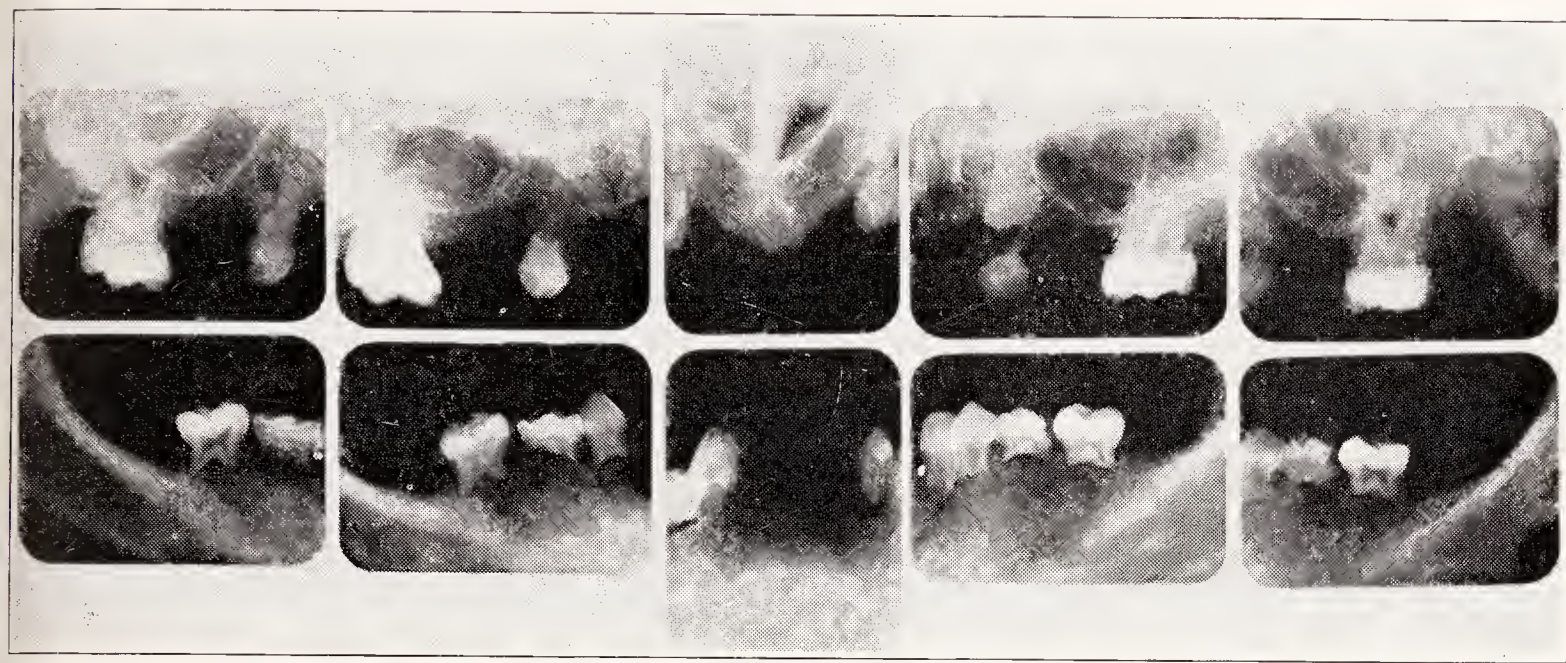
Radiographs of a girl, aged thirteen years, with almost complete anodontia. The only teeth present are several deciduous teeth and three upper permanent molars. Note the extensive resorption of the deciduous teeth in spite of the absence of permanent teeth. (Porter and Edwards, Jour. Am. Dent. Assn.)
